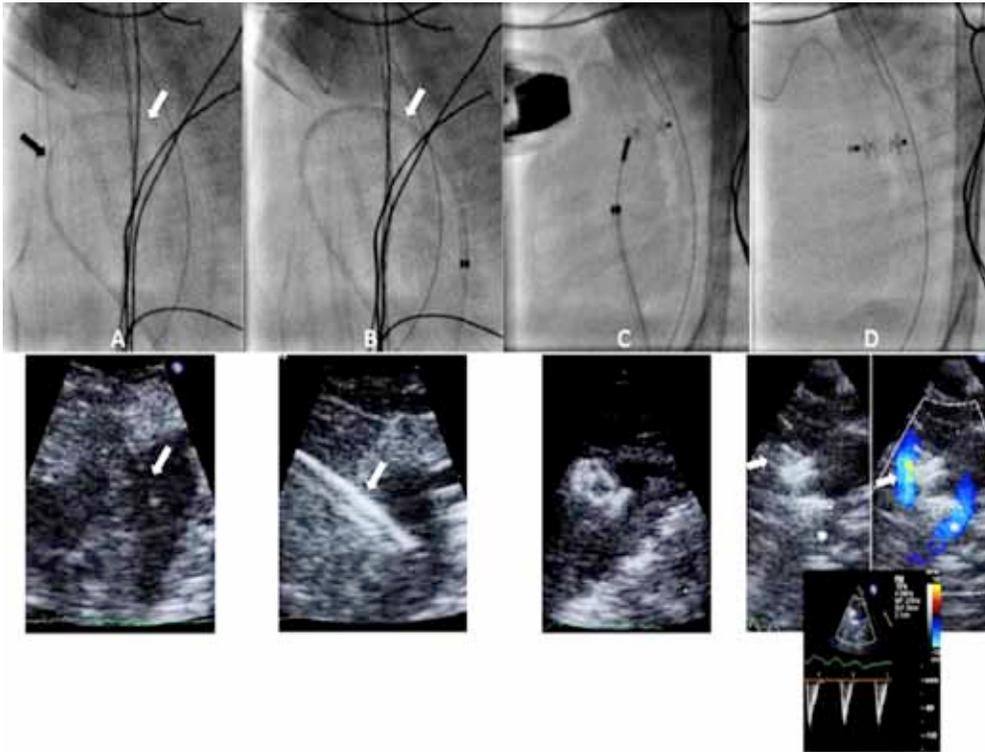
Device implantation sequence. Lateral fluoroscopic (top row) and corresponding transthoracic echocardiographic images (bottom row) of the implant procedure. (A) A 0.014 guide wire (white arrow) has been advanced from the femoral vein across the PDA into the descending aorta and a 4 F long sheath (black arrow) is being advanced over the guide wire through the right heart. (B) Once the dilator has been removed, the delivery sheath (white arrow) can be seen clearly by both imaging modalities as it crosses the PDA. (C) Following deployment, but prior to release from the delivery cable, all 3 components of the AVPII can be visualized and a careful assessment of position made. (D) Both 2 dimensional, color and pulsed wave Doppler are utilized to ensure that the PDA is closed and that normal flow is maintained in the LPA (white arrow) and descending aorta (*).
